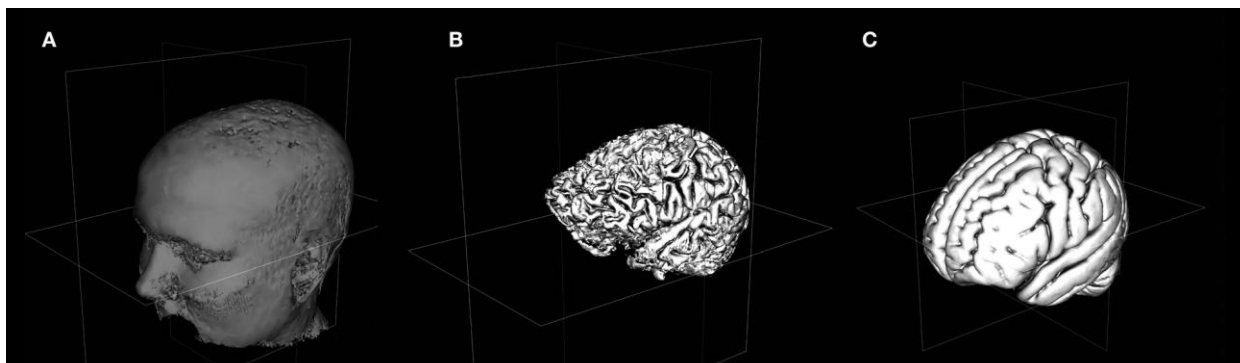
Extracting surfaces from volumetric data. Isosurface techniques, the ability to extract a surface based on ‘joining the dots’ of manifold at a single scalar value in a volumetric dataset, can be used to extract the scalp (A) or cortex (B) in high resolution structural MRI data in matter of seconds. (C) The equivalent cortical surface extraction for the MNI brain. Adapted from Gouws et al., 2009.
